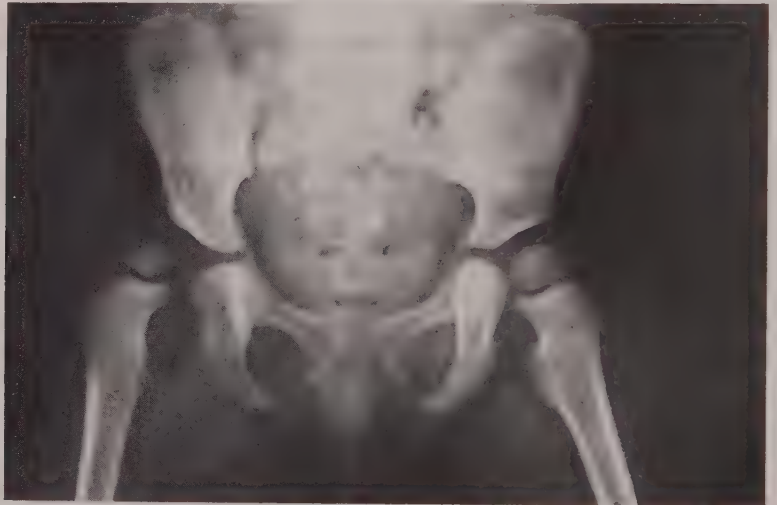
An X-ray showing congenital dislocation of the right hip.
